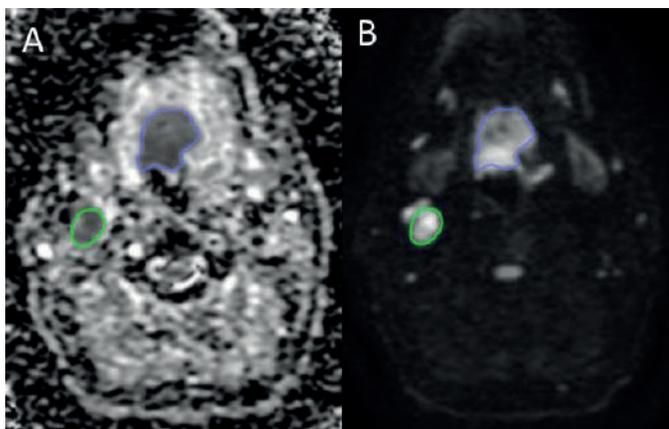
Example of whole-lesion segmentation DWI on the A) ADC map and B) $b1000$ imaging. Delineation was performed in areas with low signal intensity on the ADC map and high signal intensity on the $b1000$ images in accordance with anatomic sequences
